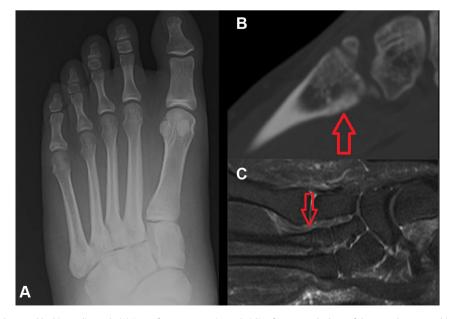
(A) Stress fracture with normal looking radiograph. (B) Stress fracture appearing as hairline fracture at the base of the second metatarsal (arrow). (C) Stress fracture shown as bone marrow oedema at the base of the second metatarsal (arrow).
